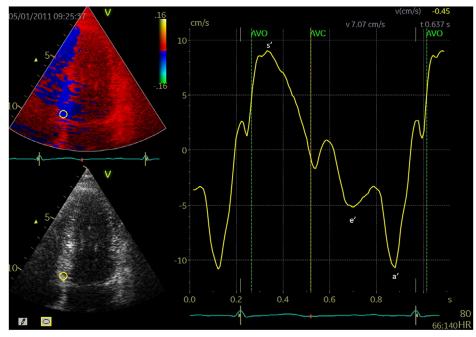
Myocardial tissue velocities by color tissue Doppler echocardiography. The figure shows an example of a typical profile of a myocardial velocity curve with a sample placed at the base of the septal wall. There is a peak systolic tissue velocity (s'), and 2 peak velocities -early (e') and late (a') - in diastole. AVC: aortic valve closure AVO: aortic valve opening.
